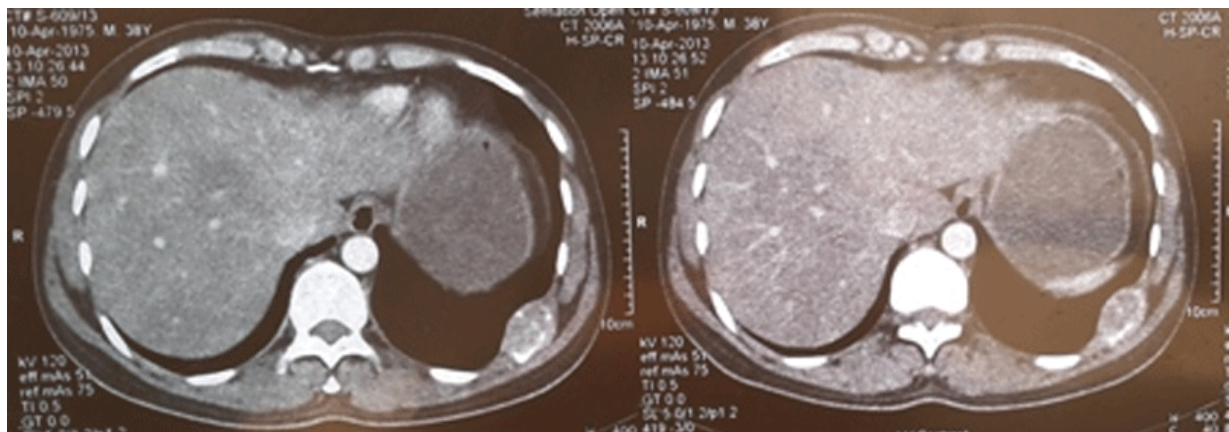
Computed tomography chest showing destructive lesion involving posterior end of 9th rib
